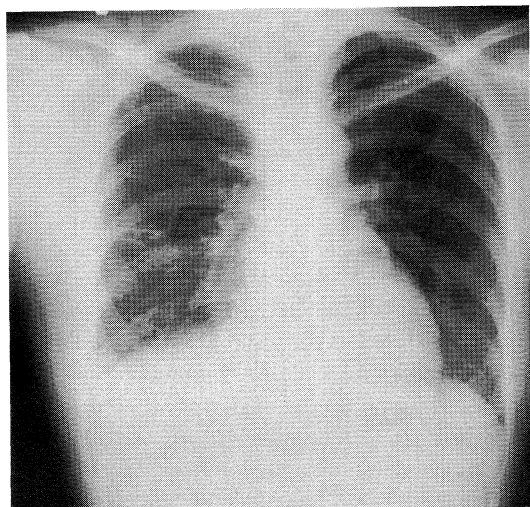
Chest X-ray on admission shows right pleural effusion and calcification beneath the right hemidiaphragm.
